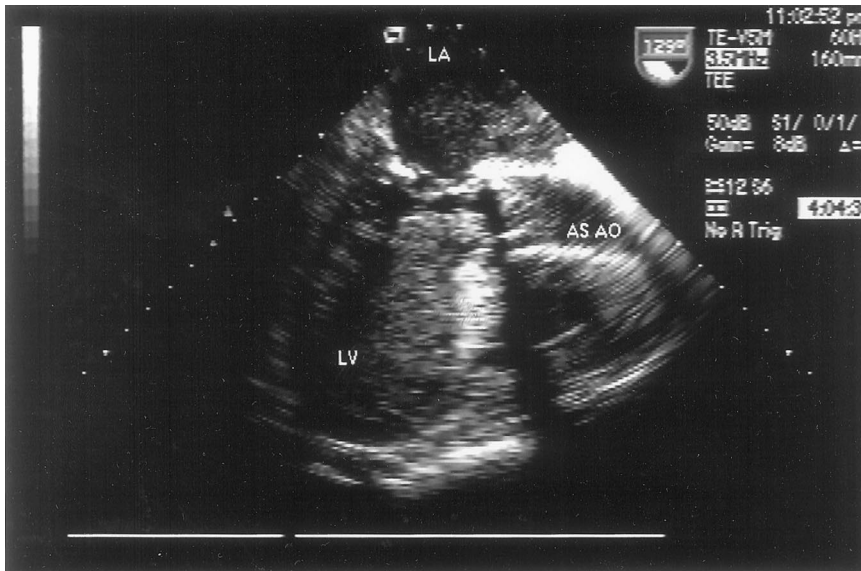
Transesophageal echocardiographic image of the left atrium (LA), left ventricle (LV), and ascending aorta (AS AO), showing a large thrombus extending across the mitral valve and aortic valve and completely occluding flow.
